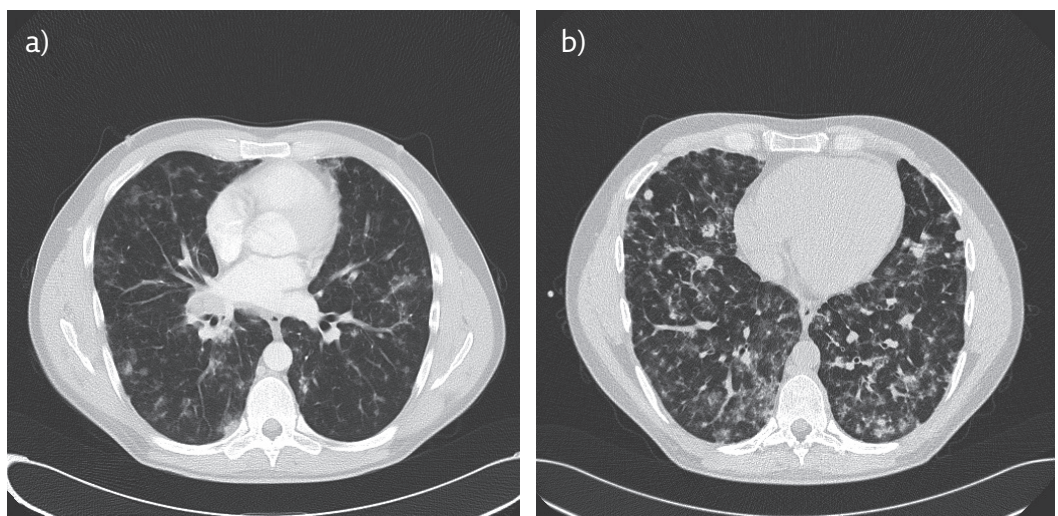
a) Contrast-enhanced chest CT parenchymal window. b) High-resolution CT during inspiration.
